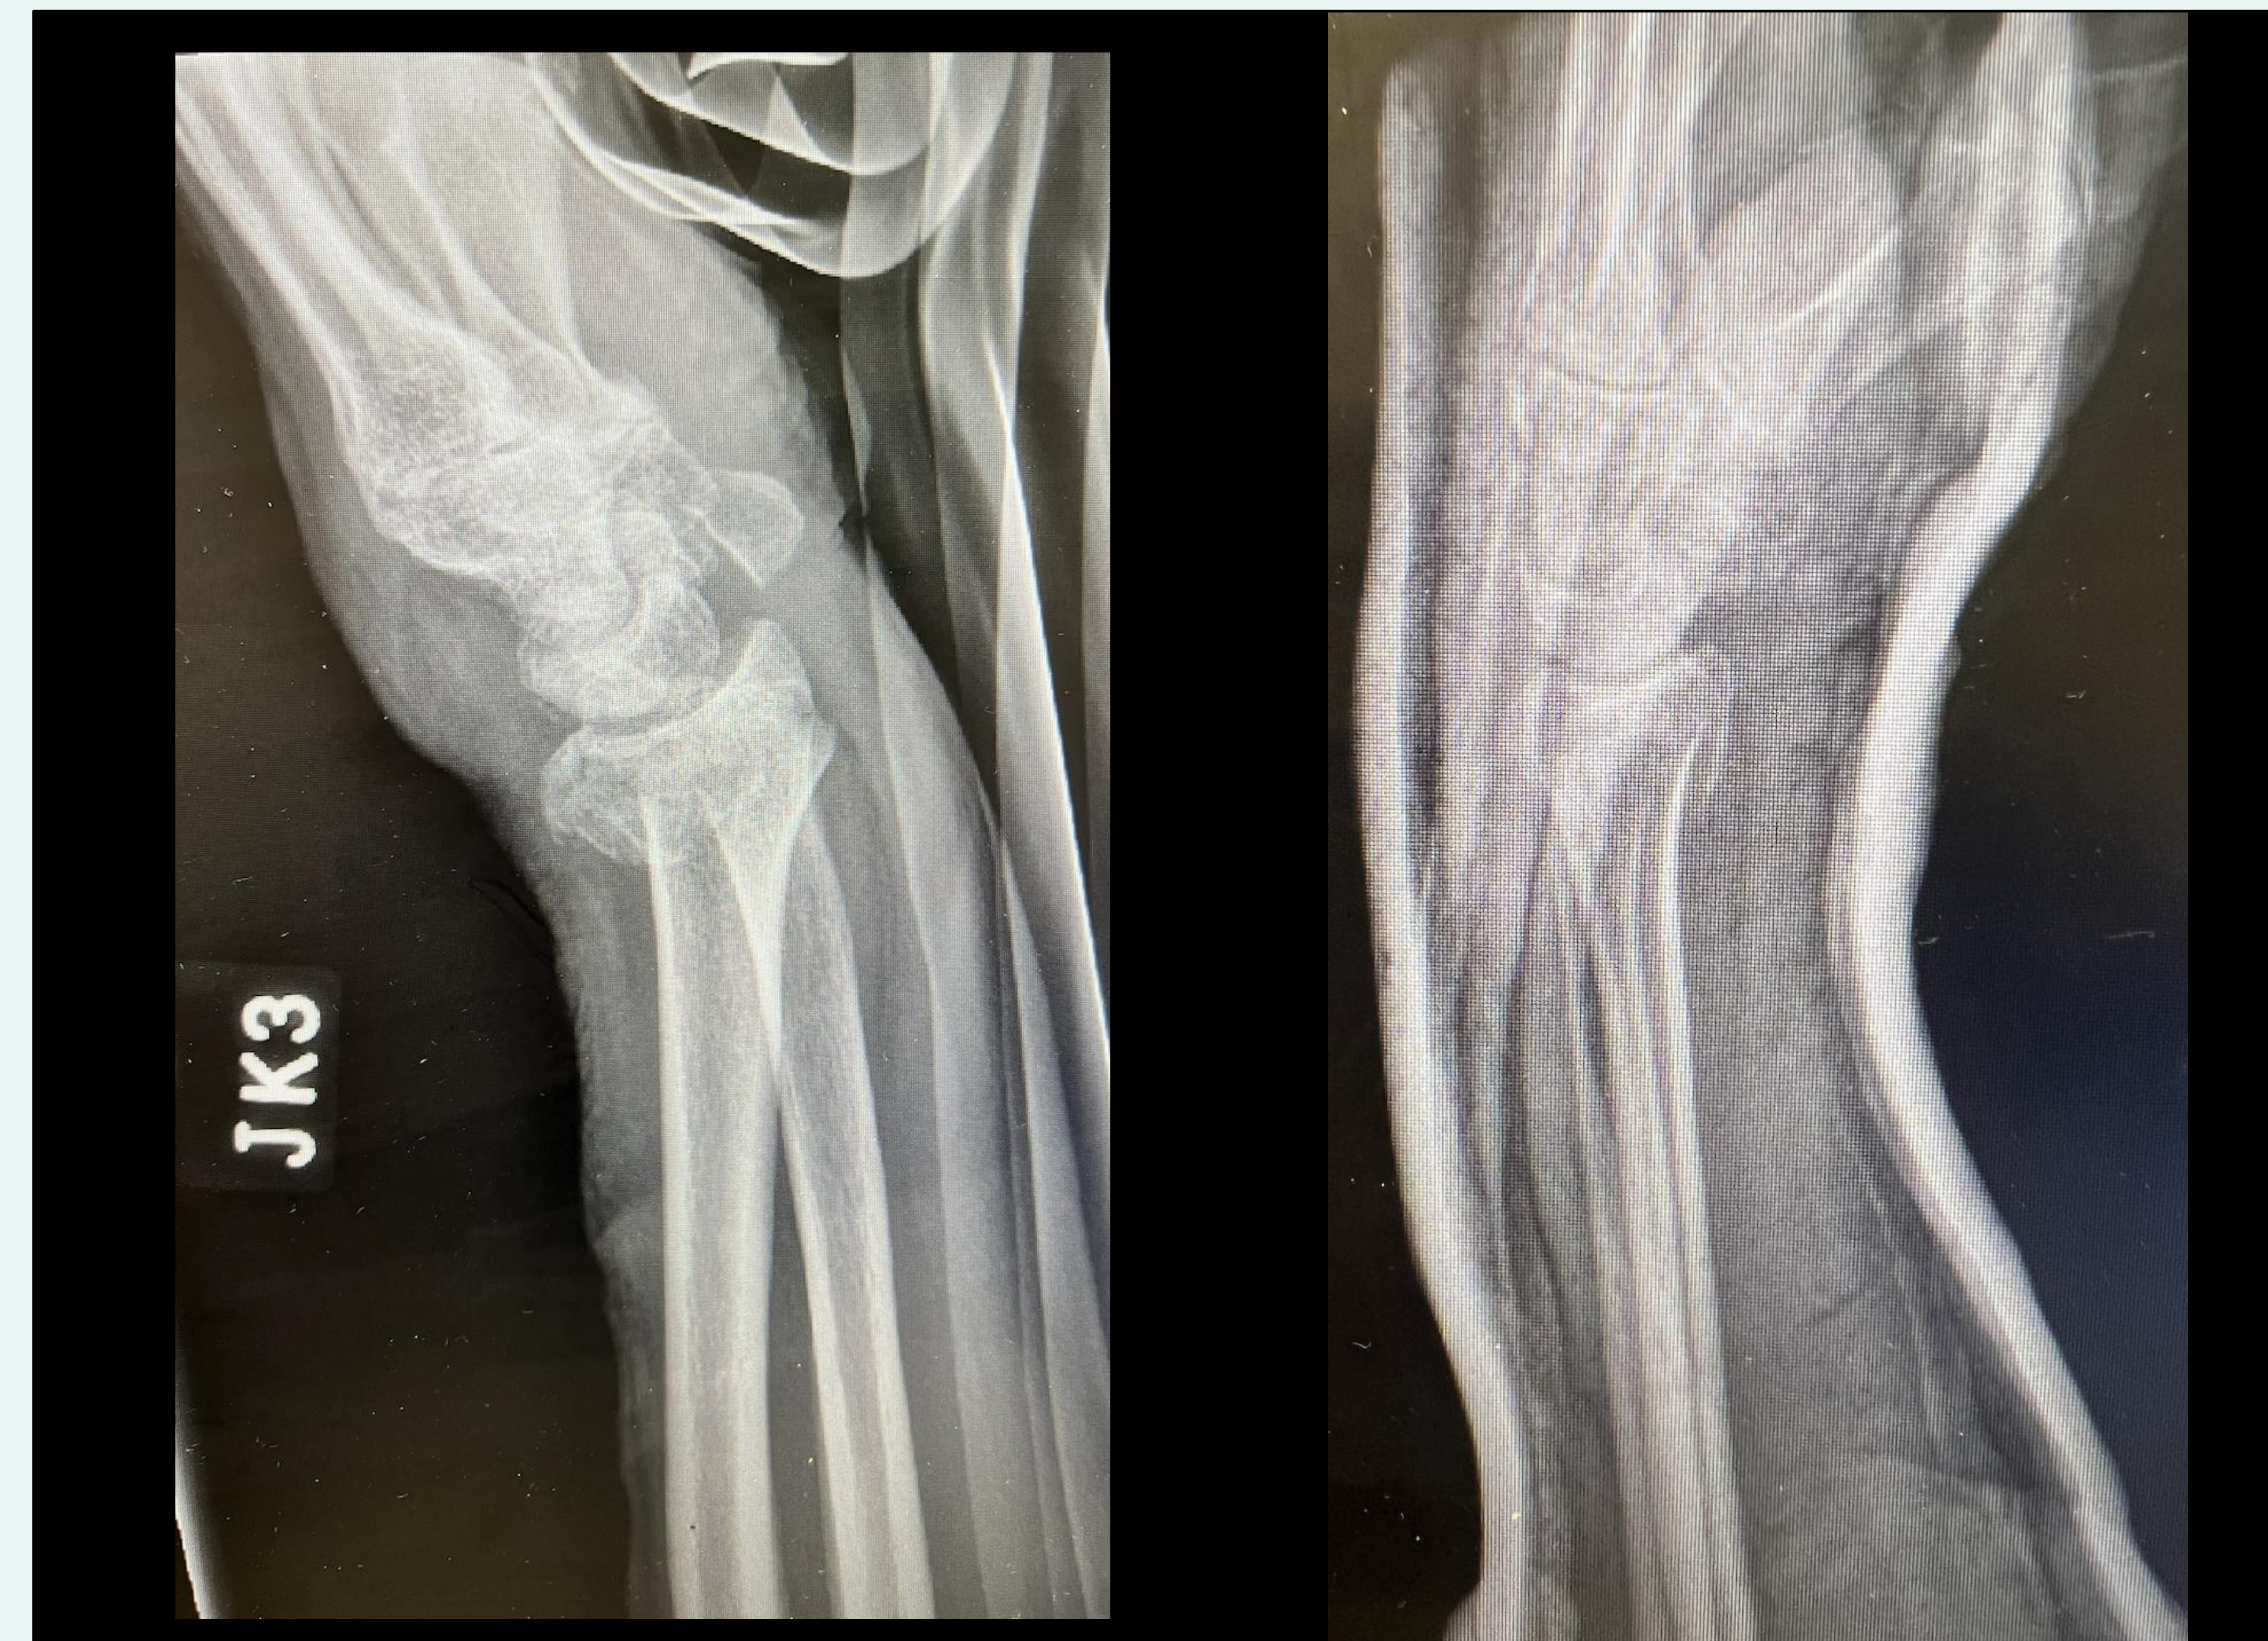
Pre- and post-reduction radiographs of a distal radius fracture placed in a reverse sugar-tong (short-arm) splint.
